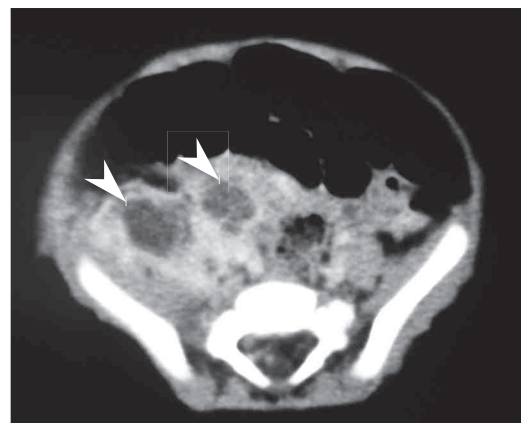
Enhanced CT finding
